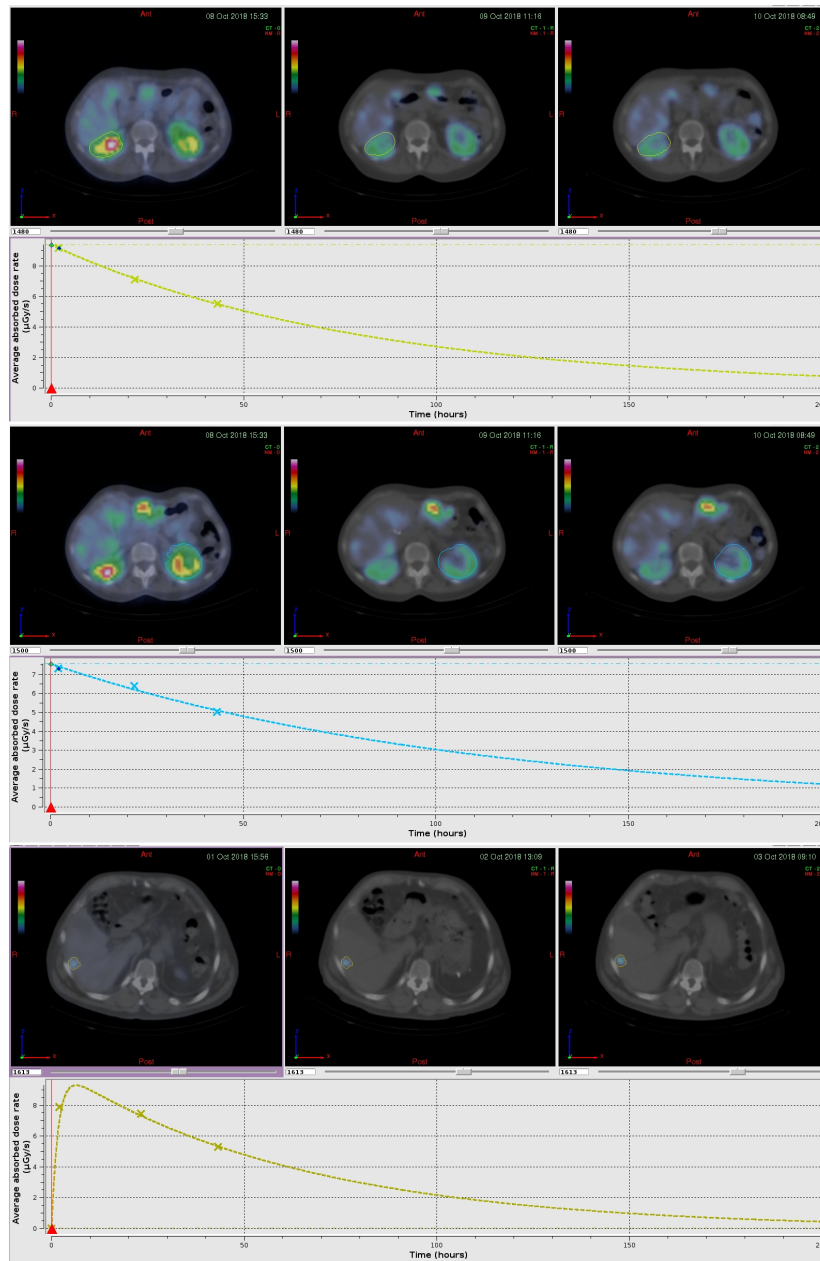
PlanetDose: right kidney (top), left kidney (middle) and tumor lesion (bottom) contours displayed on the transverse views of the coregistered SPECT/CT studies at 1h, 24h and 48h. The dose-rates as a function of time for each are also displayed below each VOI.
